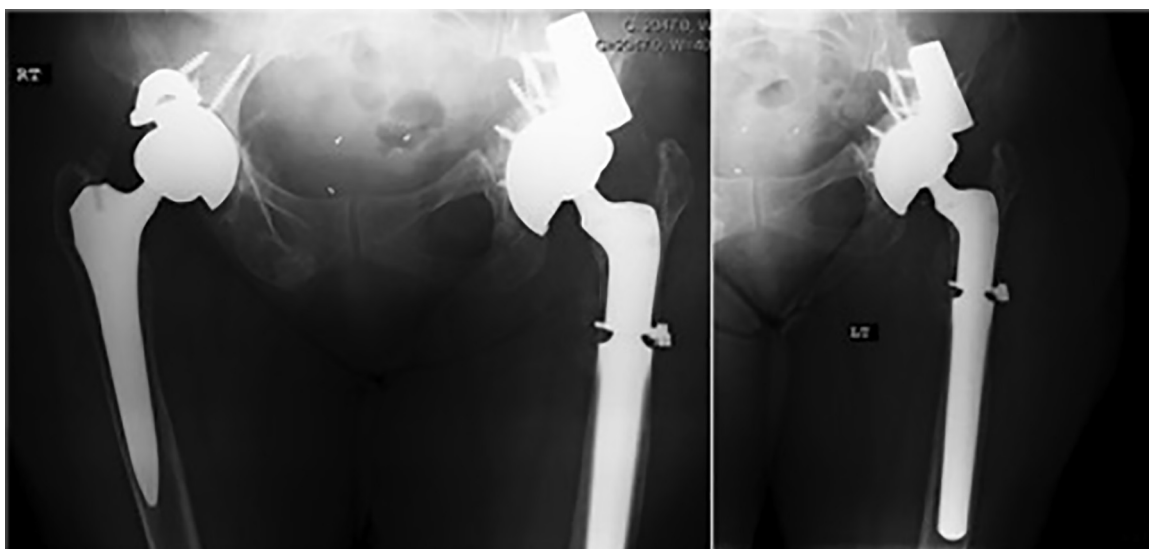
Pelvic AP radiograph and AP of the left hip 1-year status post left hip revision THA. Note the complete graft incorporation and stable bone-implant osseointegration, with no signs of loosening/osteolysis/graft resorption.
